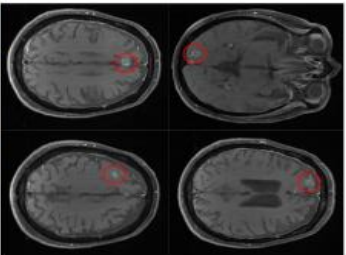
MRI of 4 brain lesions (red circles)
